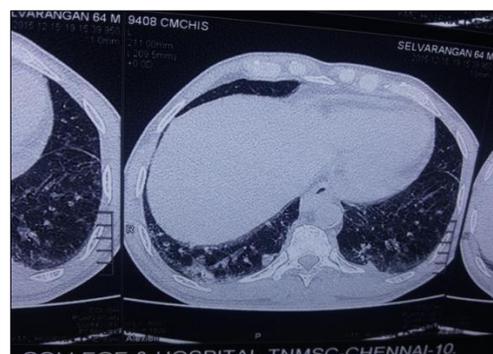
CT- chest plain showed bilateral cavitary lesion more right >left
